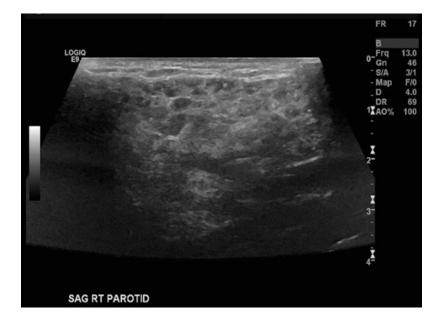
Parotid ultrasound showing characteristic findings of chronic sialadenitis including hypodense fluid collections surrounded by hyperintense scar
